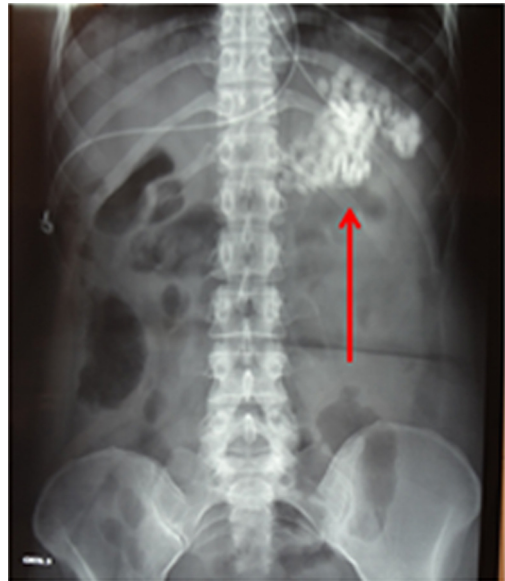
Abdominal radiography with multiple radioopacities in the stomach (red arrow).
